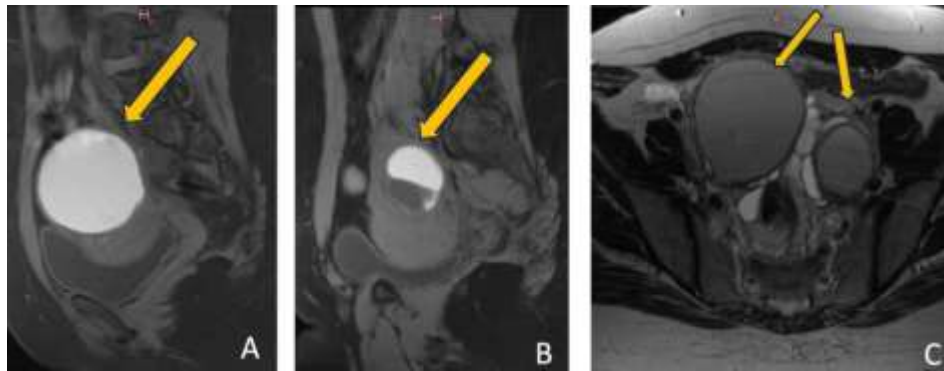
MRI revealed bilateral ovarian cysts containing fluid with high T1 signal intensity in sagittal T1WI with fat saturation (right “image A”, left “image B”) and T2 signal drop, consistent with the T2 shading sign (axial T2WI “image C”), consistent with blood content and suggestive of endometriomas.
